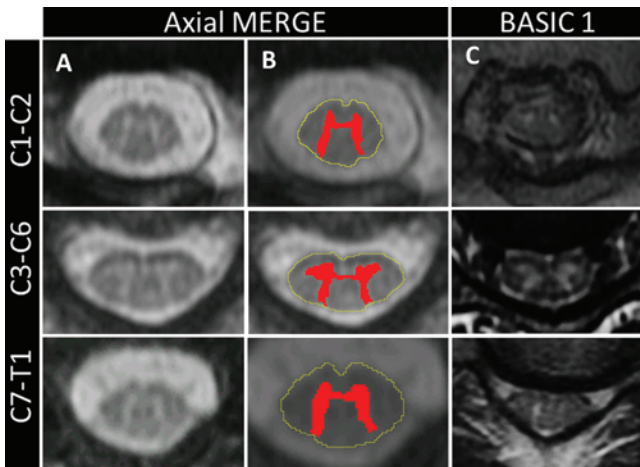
Familiarity with the normal spinal cord gray matter morphology at rostral (C1–C2), middle (C3–C6), and caudal (C7–T1) cervical vertebral levels is important for rating an SCI as BASIC Score 1. A: Axial multi-echo recombined gradient echo (MERGE) image of the normal spinal cord clearly indicates the normal gray matter morphology at the upper, middle, and lower cervical vertebral levels. B: Manual segmentation of cervical spinal cord gray matter based on an axial MERGE images in A with the peripheral cord contour delineated in yellow. Note the large frontal horns related to the cervical enlargement at the C3–6 vertebral levels. C: Axial T2-weighted images from the epicenters of BASIC Score 1 SCIs at the upper, middle, and lower cervical vertebral levels. Note that the T2 hyperintensity represents the approximate boundaries of spinal cord gray matter for each cervical level. Figure is available in color online only.
